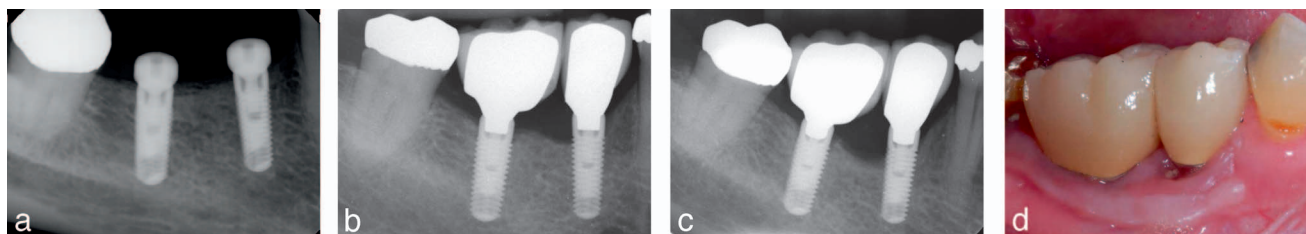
FIGURE A 67-year-old Caucasian female received dental implant placement to replace the missing teeth #29 and #30. (a) Periapical radiograph was taken at the time of implant placement. (b) Another periapical radiograph was taken 1 year after definite restoration. This periapical radiograph is served as a baseline radiograph to represent radiographic bone level. (c) Periapical radiograph taken 2 years after crown delivery showed progressive peri-implant bone loss at distal aspect of #29. No apparent peri-implant bone loss was seen at #30. (d) A clinical picture taken 2 years after crown delivery showed inflamed peri-implant tissue with suppuration at #29 and #30. Based on the proposed multi-domain scale, #29 was determined with peri-implantitis and #30 was determined with peri-implant mucositis.
